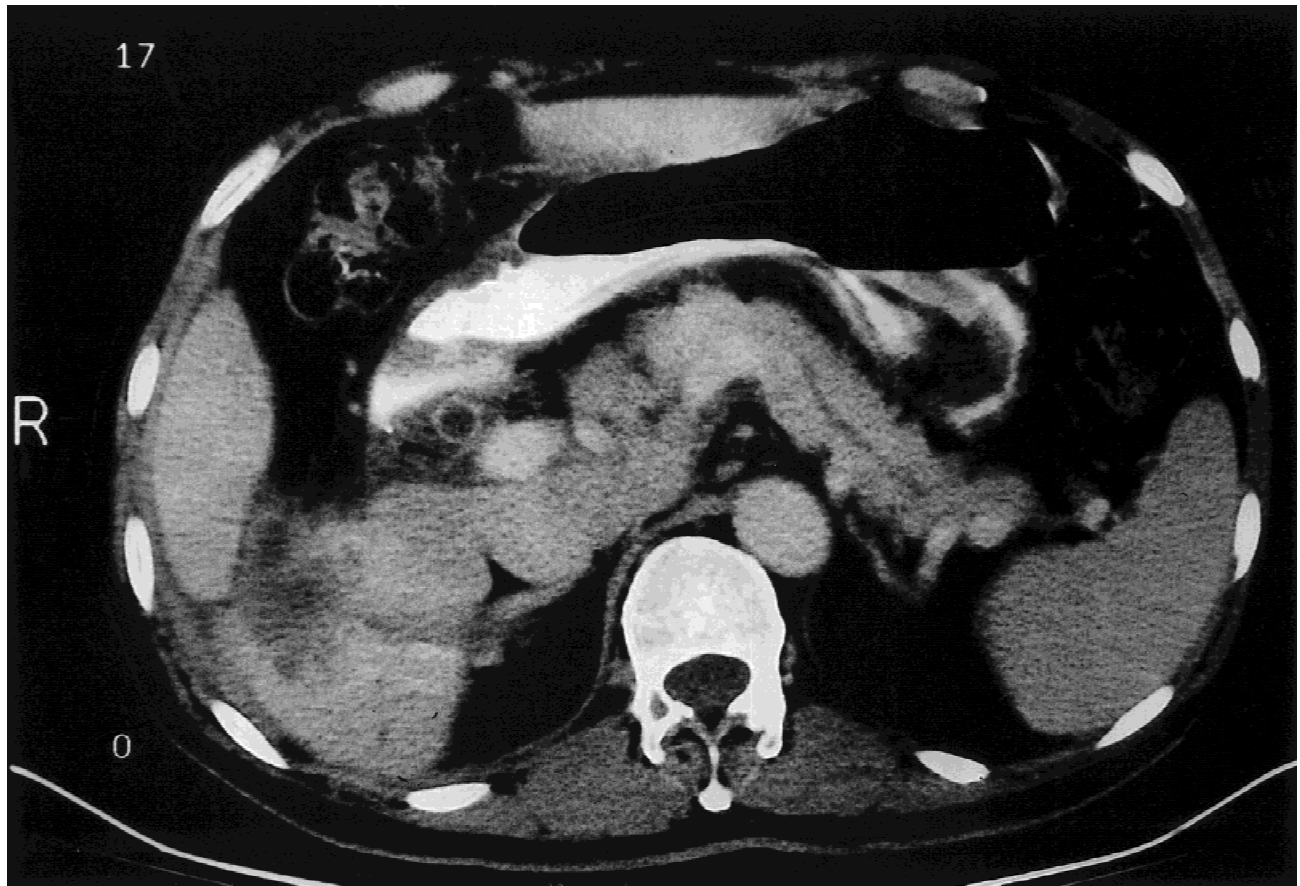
CT scan showing prominent, clot-filled common bile duct and abnormality of posterior abdominal wall.
